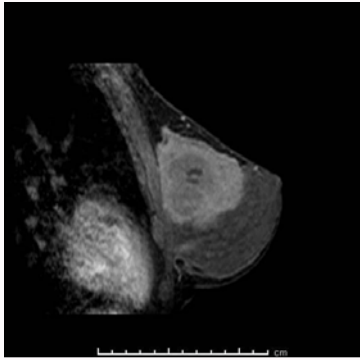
Sagittal contrast enhanced MRI of the left breast shows an irregularly marginated heterogeneously high enhancing mass, in the upper and central quadrants.
